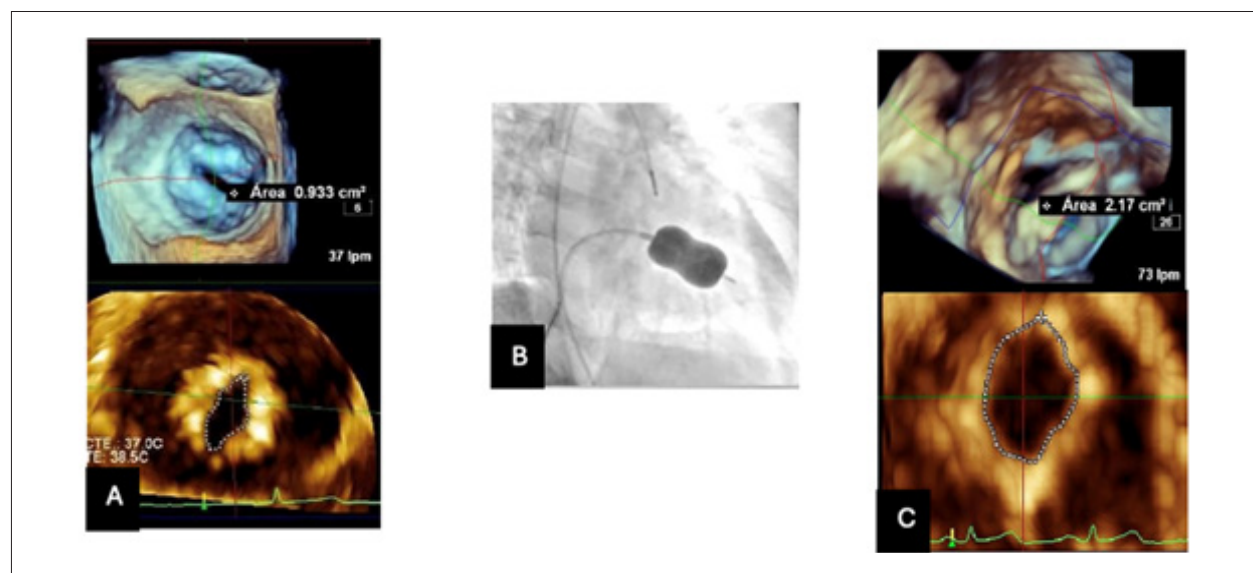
Three-dimensional transesophageal echocardiography shows the MVA before valvuloplasty: 0.9 cm² (Image A). Balloon inflation during PMBV (Image B). Postprocedural 3-dimensional transesophageal echocardiography demonstrates an increased MVA of 2.17 cm², with significant improvement (Image C).
